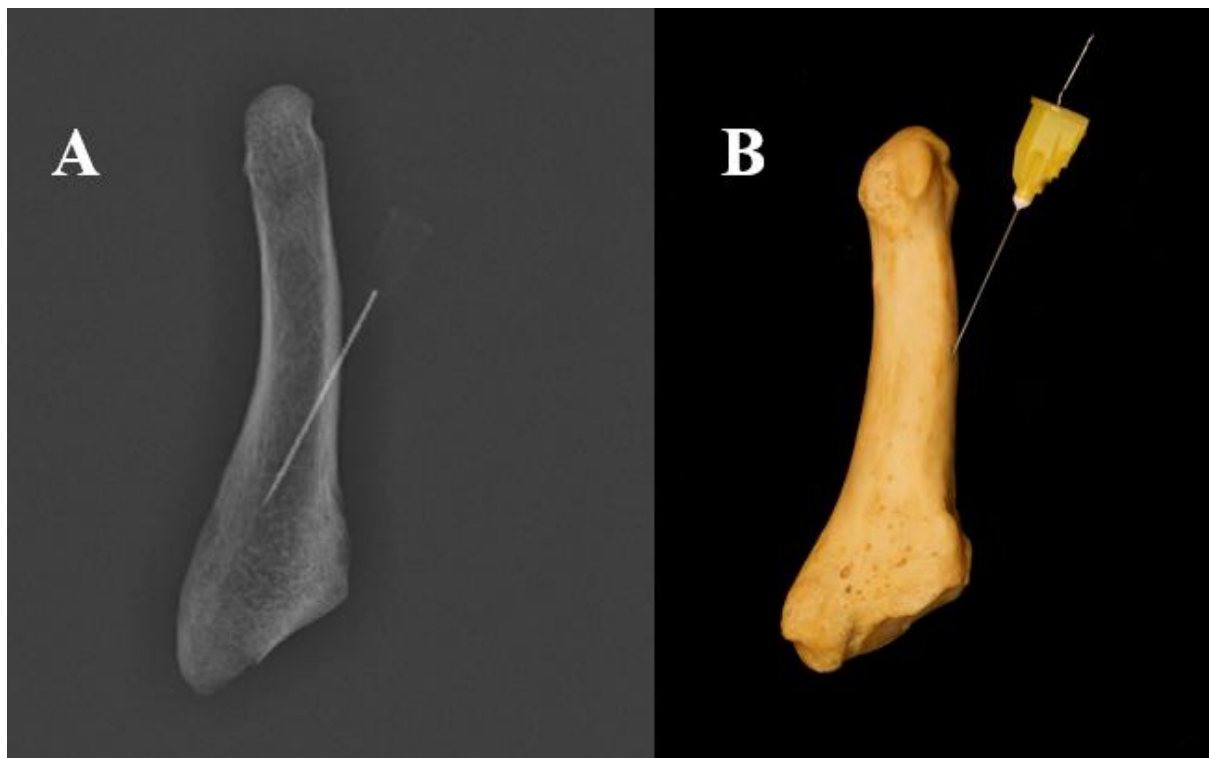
A plate of photographs showing the patency of the diaphyseal nutrient canal on the fifth metatarsal bones. A=x-ray patency confirmation. B=physical patency confirmation.
